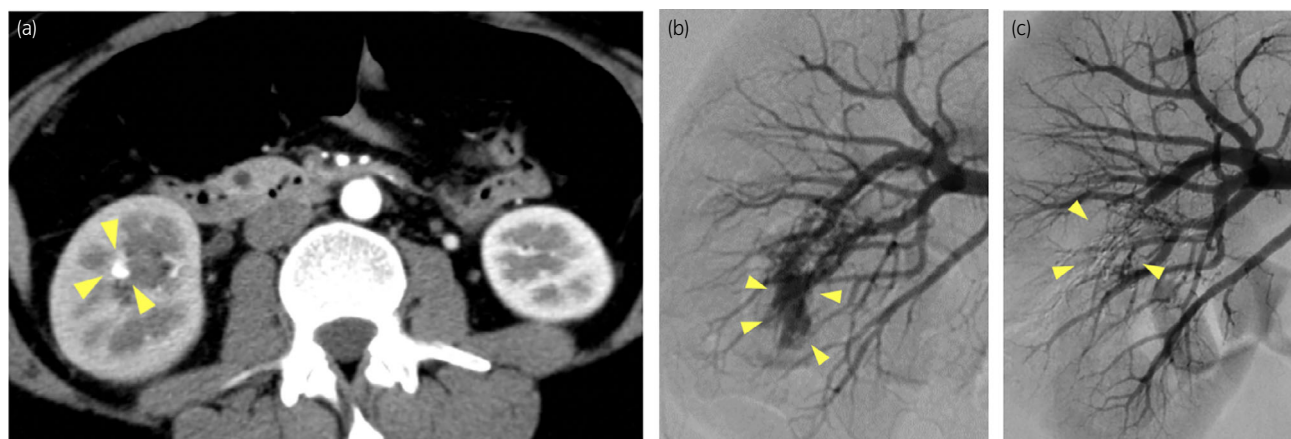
Contrast-enhanced computed tomography (a) and angiography (b, c) in Case 1. (a) The yellow triangles indicate dilated blood vessels in the arterial phase. (b) The yellow triangles indicate an abnormal complex arteriovenous network in a branch of the right middle pole renal artery. (c) The abnormal blood vessel network disappeared after selective renal artery embolization.
